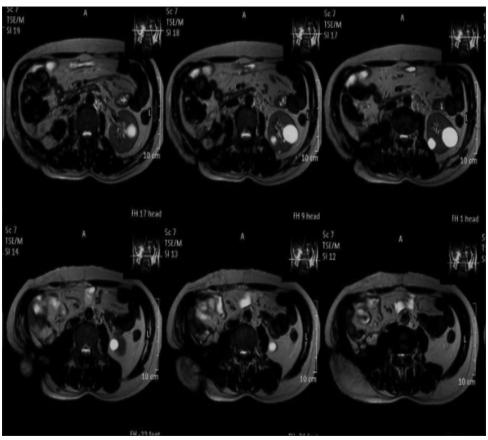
T2 fat suppressed magnetic resonance imaging revealing an irregular hyperdense collection in right paraspinal muscles, retroperitoneum on L2-L3 level with a tract descending from it posteriorly and inferiorly up to subcutaneous plane
